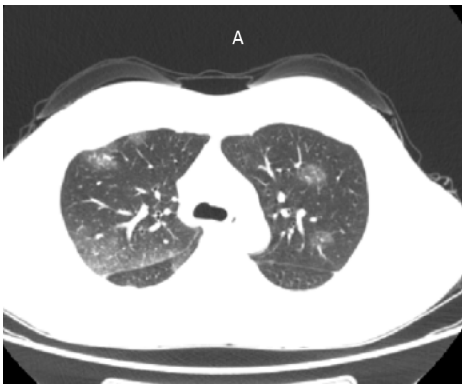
Computed tomography of the chest and upper abdomen reveals bilateral pleural effusion, with suspected involvement of inflammatory exudates.
